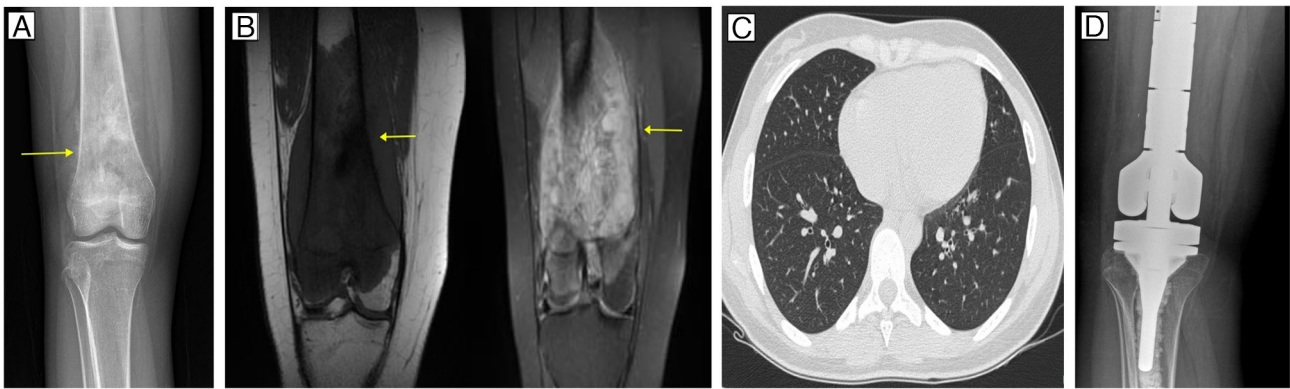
Imaging findings of the patient at diagnosis and after tumor resection. (A) Radiography revealed a blastic lesion located in the metadiaphyseal region of the right distal femur with a sunburst periosteal reaction (arrow). (B) Magnetic resonance imaging of coronal section showing a solid mass lesion accompanied by mild involvement of soft tissues (arrows): T1-weighted image (left); fat-suppressed T2-weighted image (right). (C) Axial computed tomography of the chest revealed no pulmonary metastasis. (D) Endoprosthesis reconstruction after tumor resection.
